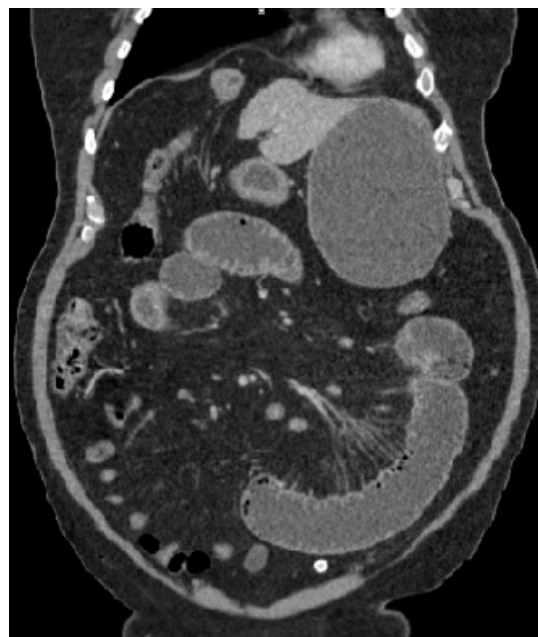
Computerized tomography (CT) image after 4 days of pain, vomiting and diarrhea with first emergency room evaluation. CT demonstrated a fluid-filled, enlarged stomach and mildly dilated and fluid-filled loops of the mid and proximal small intestine.
